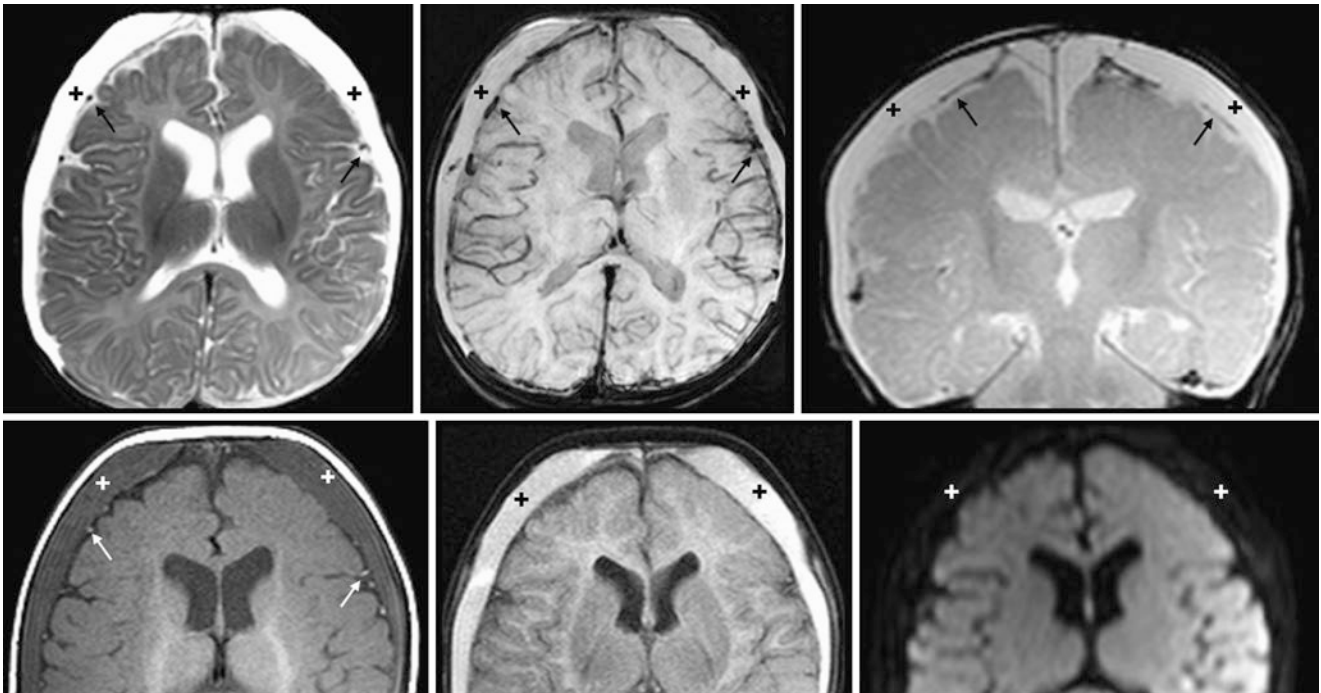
Comparison case of subdural hematomas or hygromas in nonaccidental trauma (NAT). On 3T MRI, a 4-month-old with a history of NAT had bilateral collections (*plus signs*) on T2WI (*top left*), SWI (*top middle*), coronal GE T2*WI (*top right*), T1WI (*bottom left*), FLAIR (*bottom middle*), and DWI (*bottom right*), which did not suppress on FLAIR. Note the cortical veins displaced inwards (*thin arrows*)
